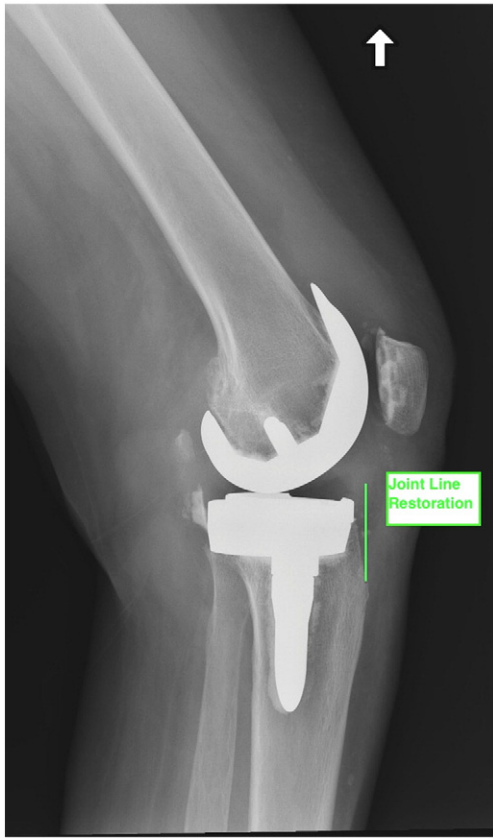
Figgie method measuring joint line restoration on lateral radiograph.
